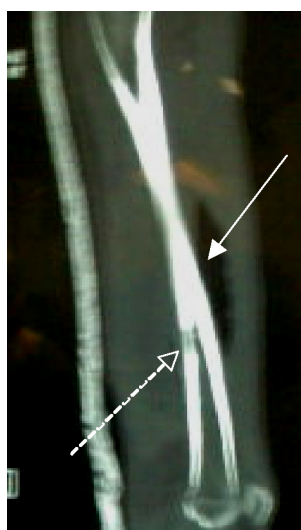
Sagittal computed tomography of right thigh shows gas in thigh (arrow) and cortical lesion (dotted arrow).
